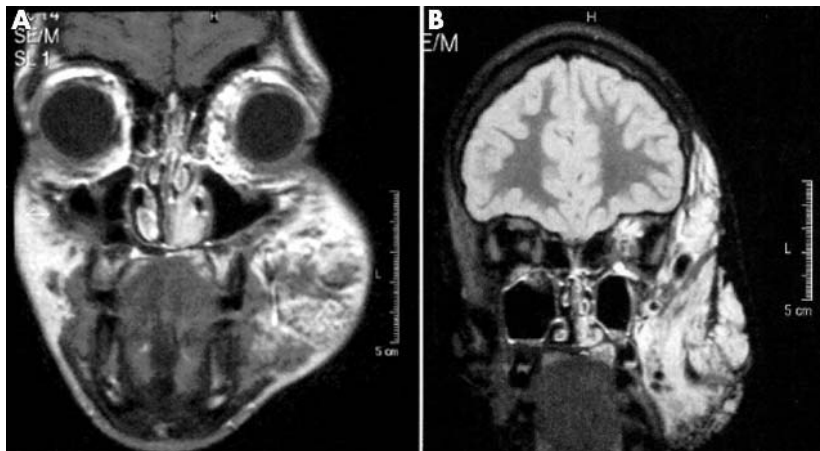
(A) Coronal T1 post-gadolinium and STIR MRI sequences. (B) Demonstrates the angiomatous lesion in left facial tissues and extending into left orbit.
